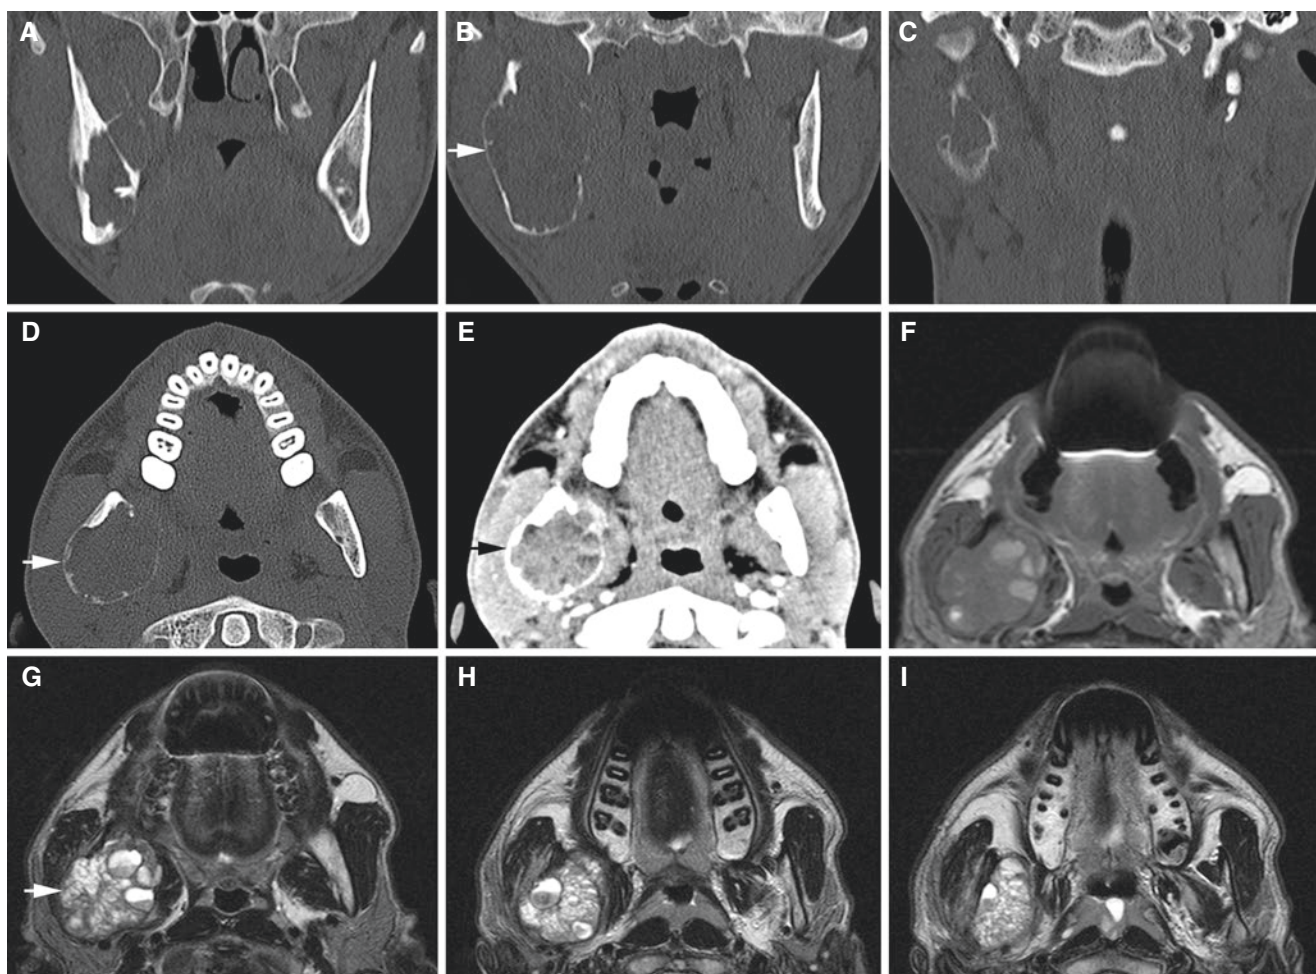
Hybrid lesion of aneurysmal bone cyst, giant cell granuloma, and ossifying fibroma, mandible; 16-year-old male with pain-free swelling of the right mandible. (A, B, C) Coronal and (D) axial CT images show expansion with thinned, partially destroyed cortical outline (*arrow*). (E) Axial contrast-enhanced (soft-tissue window) CT
